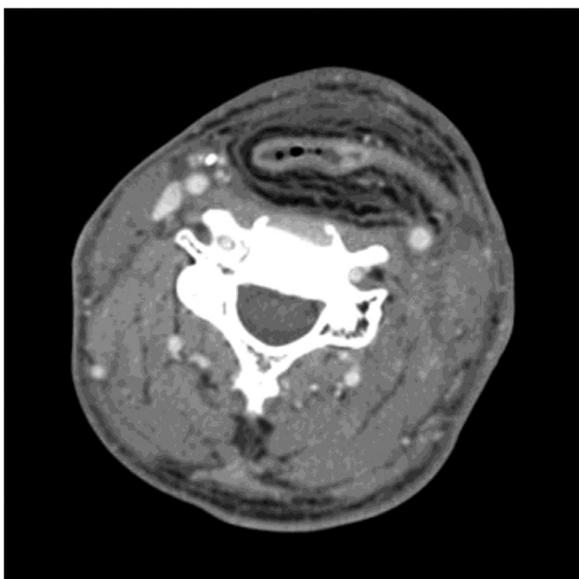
Axial image of the postoperative computed tomography scan of the patient who had a flag-shaped anterolateral thigh free flap.
